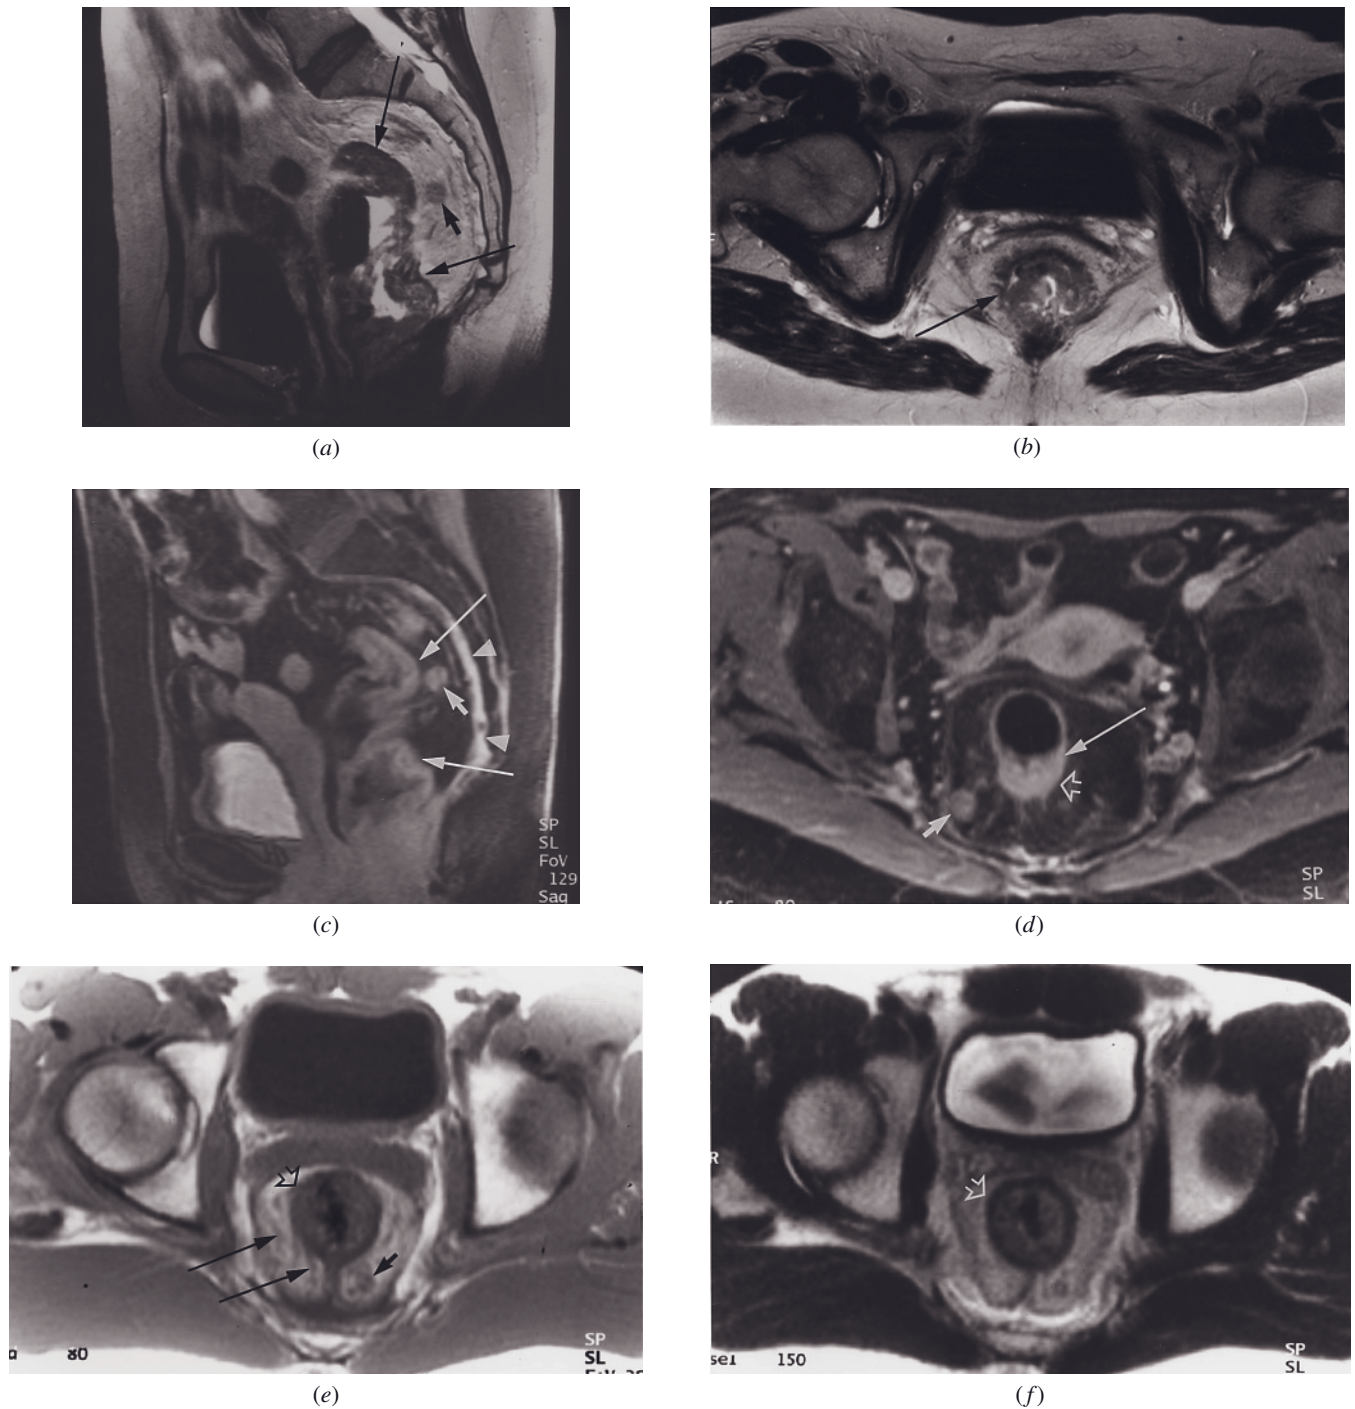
Rectal adenocarcinoma. Sagittal and transverse postgadolinium high-resolution T2-weighted echo-train spin-echo (*a, b*) and sagittal and transverse postgadolinium fat-suppressed SGE (*c, d*) images in a patient with advanced colon cancer. A large rectal cancer is present (long arrows, *a, c*). The craniocaudal extent of tumor is well shown on sagittal images (*a, c*). The tumor extends inferiorly in the rectum (arrow, *b*) to the anal verge. Lymphovascular extension with involved lymph nodes (small arrows, *a, c, d*) is present. At the superior margin, the tumor is mainly posterior in location (open arrow, *d*). The transition from normal colon to tumor (long arrow, *d*) is clearly shown. Presacral spread of tumor is shown as enhancing tissue on the sagittal gadolinium-enhanced fat-suppressed image (arrowheads, *c*). SGE (*e*), SS-ETSE (*f*), and postgadolinium fat-suppressed SGE (*g*) images in a second patient with rectal adenocarcinoma and similar imaging findings. The rectal tumor (open arrows, *e, f, g*), lymphovascular extension (long arrows, *e, g*), and perirectal lymph nodes (short arrows, *e, g*) are well shown. Sagittal and transverse postgadolinium
